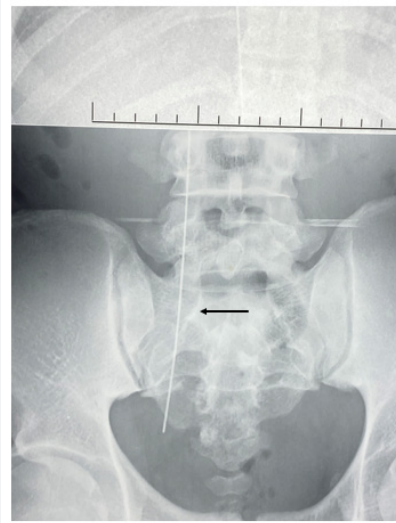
X-ray of the front pelvis showing the metal guide in the right femoral vein.
